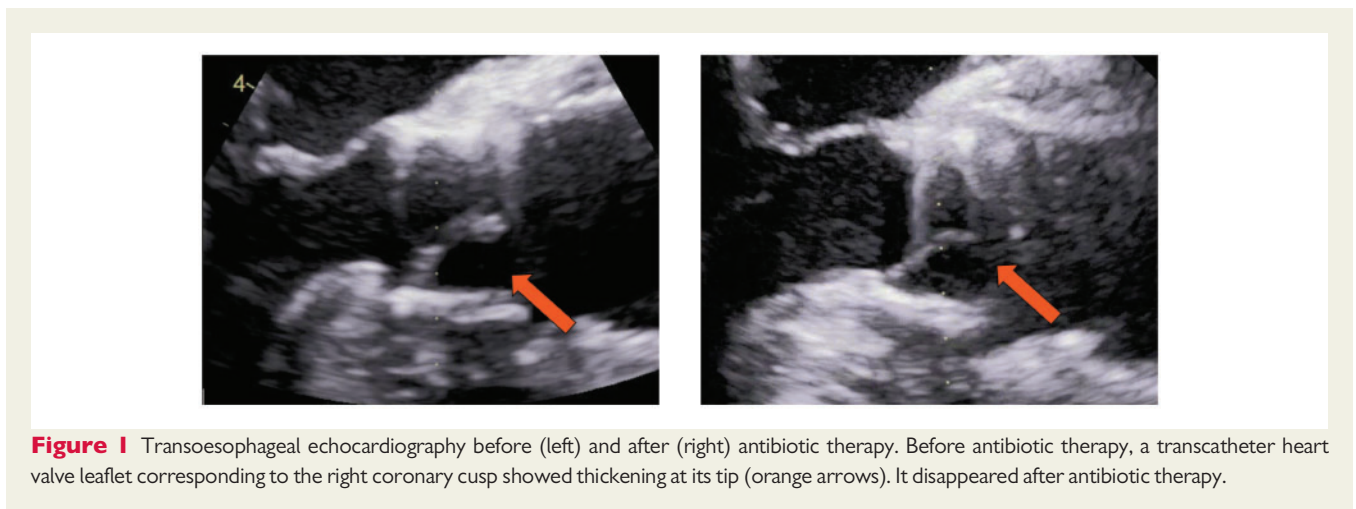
Transoesophageal echocardiography before (left) and after (right) antibiotic therapy. Before antibiotic therapy, a transcatheter heart valve leaflet corresponding to the right coronary cusp showed thickening at its tip (orange arrows). It disappeared after antibiotic therapy.
